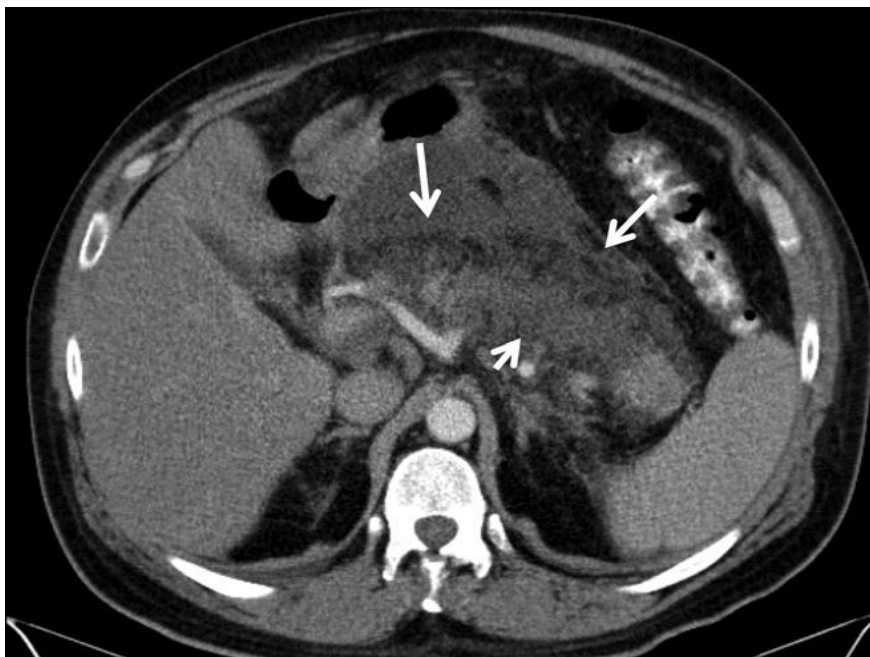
Contrast-enhanced computed tomography (CECT) imaging of acute pancreatitis. (Modified from *Banks PA et al, Gut. 2013* and *Wu BU & Banks PA, Gastroenterology. 2013*) (217,224)
